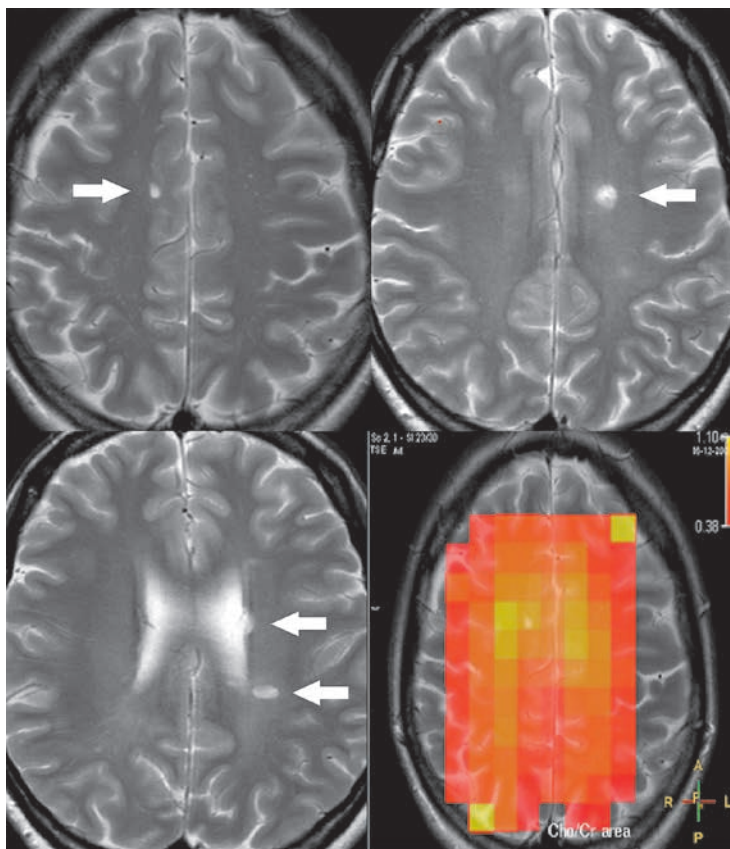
There are specific for MS lesions on MRI T2-weighted images (marked with arrows). Metabolic picture (right low corner): Cho/Cr demonstrates increasement in white matter and medial cortex middle thirds of lobes (bright yellow color)
